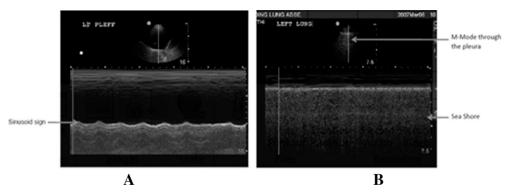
Ultrasonography on M-mode. (A) Sinusoid sign representing a pleural effusion. (B) Seashore sign representing normal pleural sliding.
